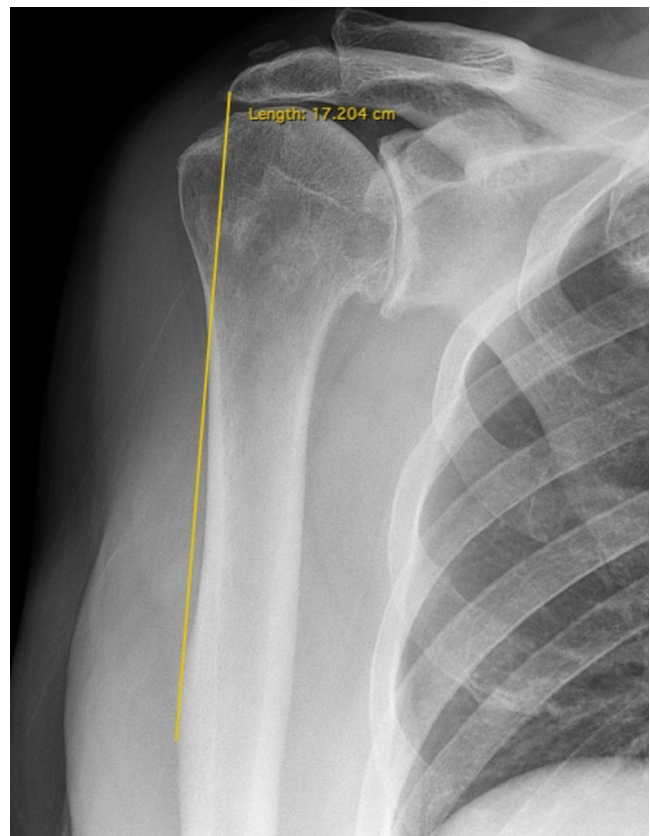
An anteroposterior Grashey radiograph demonstrating the measurement technique for deltoid length.
